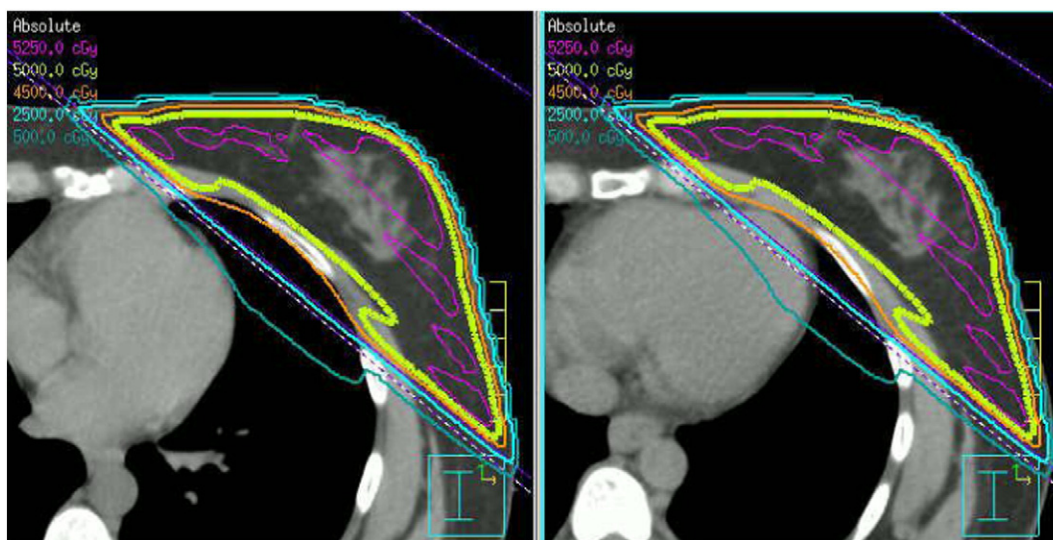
Deep inspiration breath hold computed tomography scan with isodose lines showing sparing of heart (left); free breathing computed tomography scan at same slice as deep inspiration breath hold scan showing inclusion of heart within the tangent (right).
